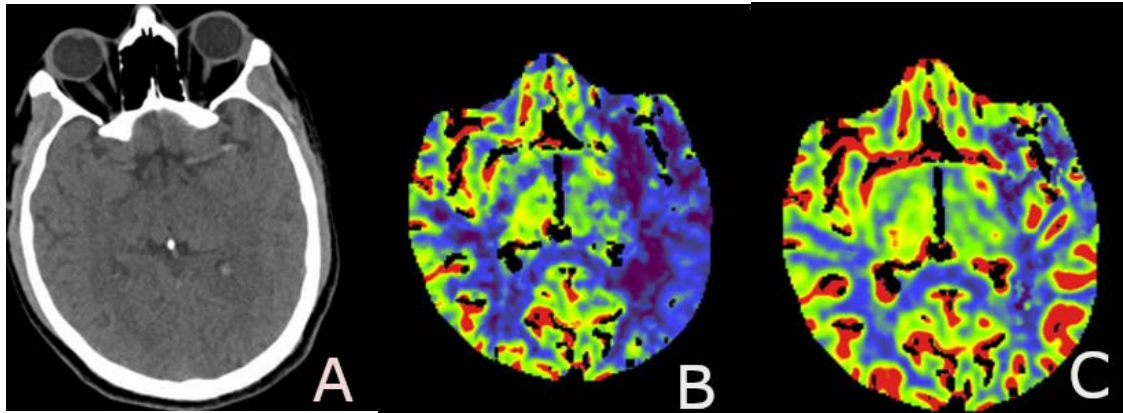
Plain CT scan showed subtle hyperdensity in the left MCA
